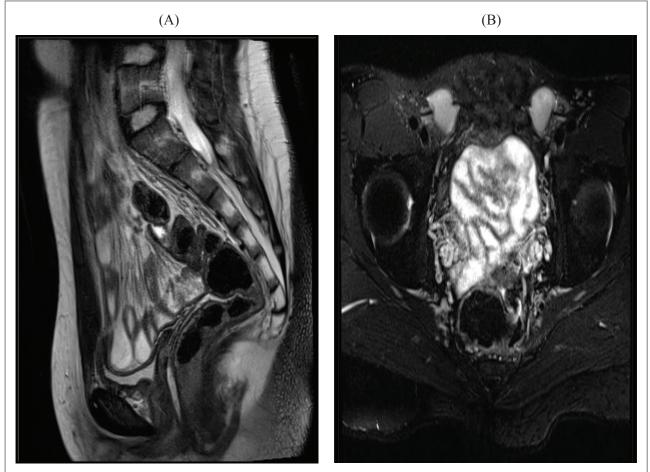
A T2 weighted magnetic resonance imaging (MRI) of the pelvis (a) showing no uterus and (b) showing testicles within the inguinal canals in a patient with complex androgen insensitivity.
